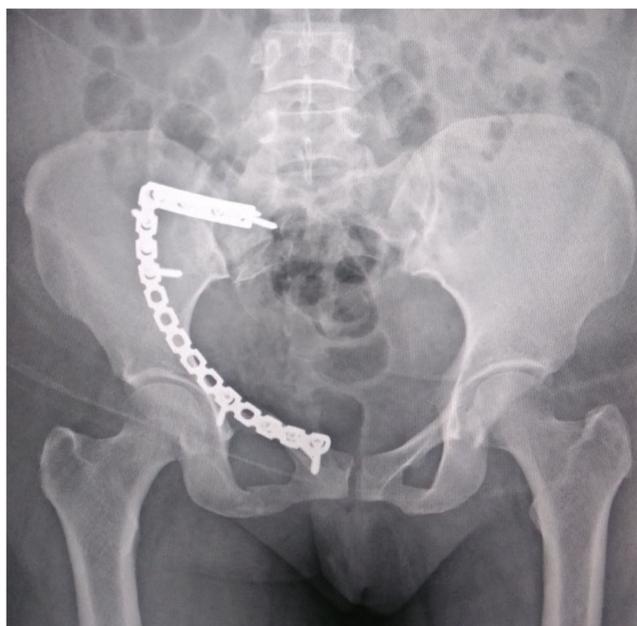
Post-operative radiograph of case 4 showing a stabilized R Hemi Pelvis
